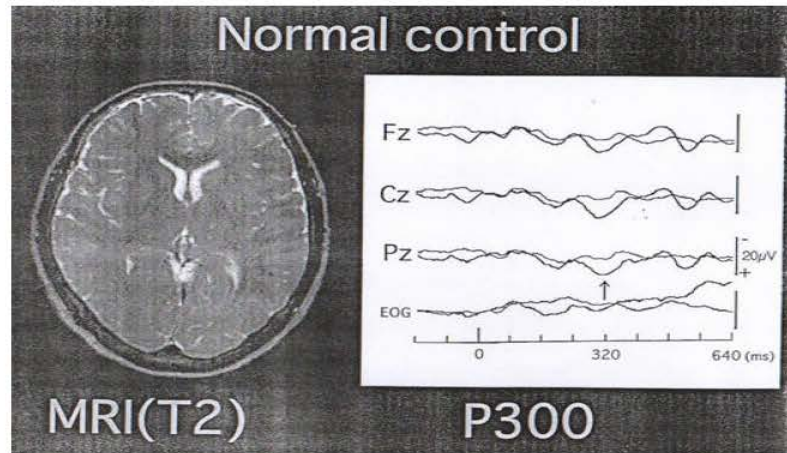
The MRI of 65 age healthy adult with the normal average waveforms of ERPs obtained from Fz, Cz, Pz and EOG in responses using a standard auditory oddball stimulus paradigm
